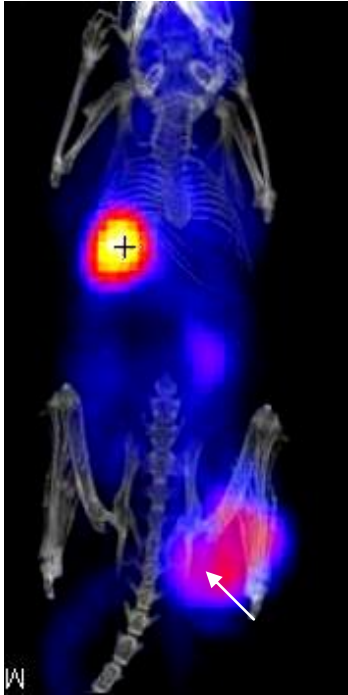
Detection of LLC primary tumour using X-ray CT and PET
